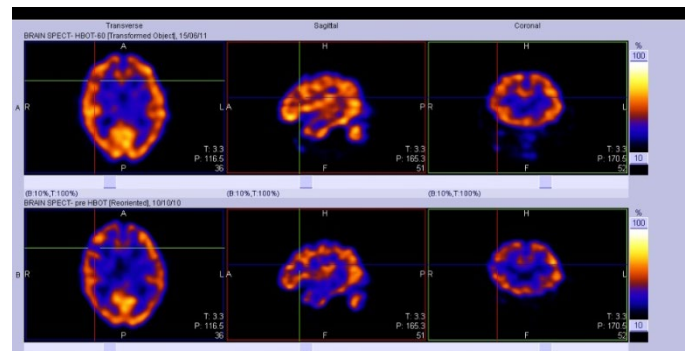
SPECT of a subject with MCI before (lower panel) and after HBOT, showing extensive increases in brain activity by SPECT
